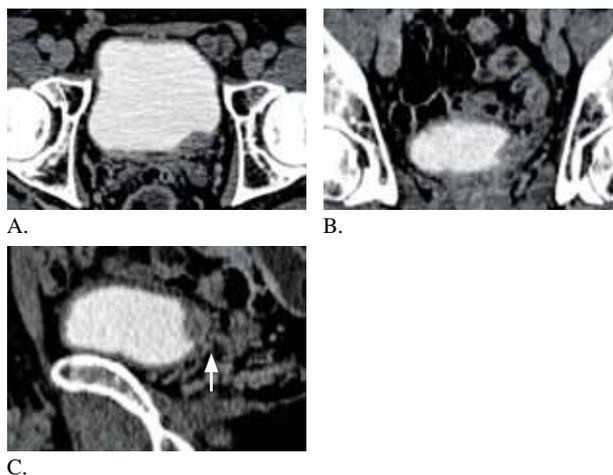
A 74-year-old man presented with gross hematuria for 1 month. An infiltrative lesion along left posterolateral site of urinary bladder wall with left UVJ involvement is depicted. This lesion is measured about 8 x 25 mm. (A,B,C axial, coronal and sagittal view) Retrograde pyelography confirmed malignant filling defect. Further CT chest revealed lung metastases.
